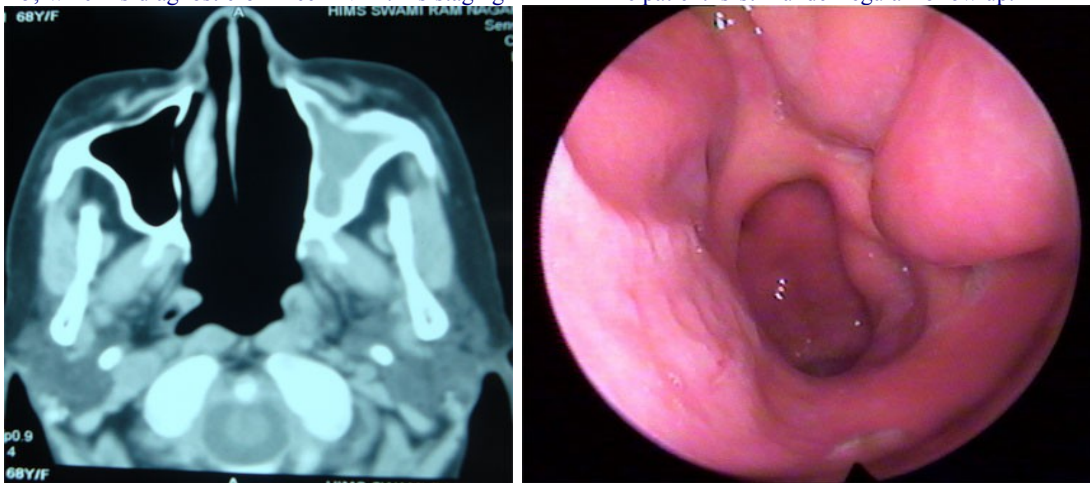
(a) CT scan (Axial) after completion of chemotherapy shows significant regression of the tumor mass. (b) 1 year after completion of chemoradiation endoscopy shows complete regression of the tumor mass. Figure 3: (a) CT scan (Axial) after completion of chemotherapy shows significant regression of the tumor mass. (b) 1 year after completion of chemoradiation endoscopy shows complete regression of the tumor mass.
